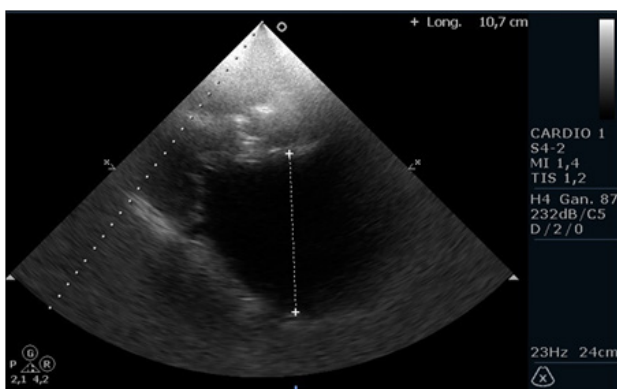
plane echocardiographic parasternal long axis observing thickening and restriction of opening of the mitral valve and anteroposterior diameter of the left atrium increased (10.7 cm)
